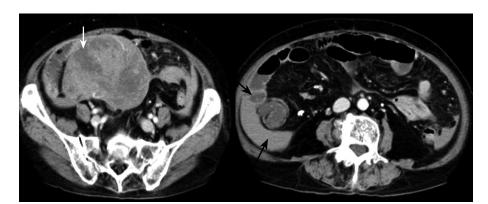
CT scan demonstrating a large heterogeneous mass with a non-uniform enhancement pattern (white arrow) in the pelvis and hemoperitoneum (black arrows).
